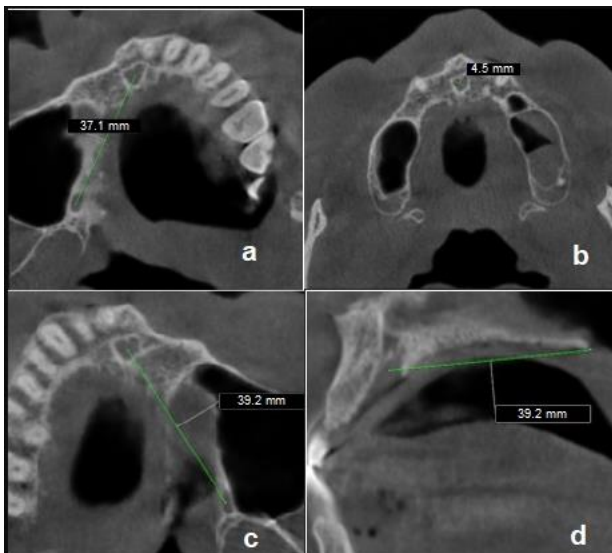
Measurement of the IF - GPF distance in CBCT axial section (a,c). Measurement of the IF diameter (b). Measurement of the distance between the IF and the PNS (d).
